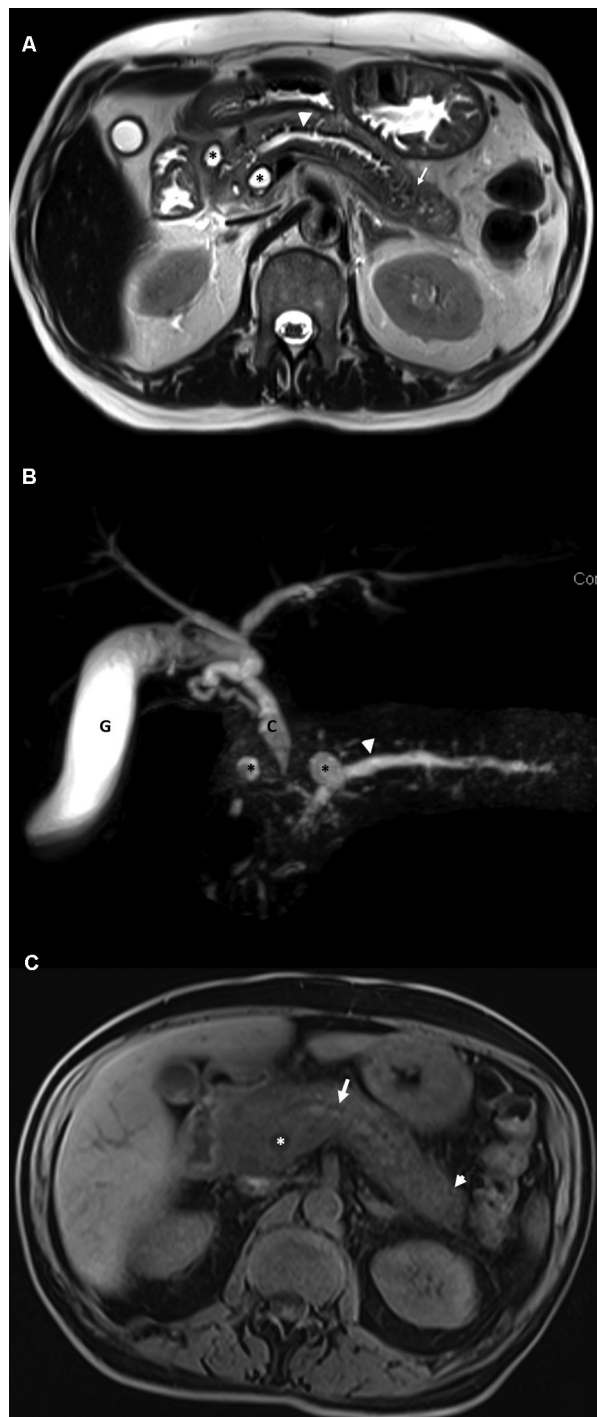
Magnetic resonance imaging (MRI) in 62/M with recurrent acute alcohol pancreatitis showing early chronic changes on MRI. (A) T2 HASTE (half-Fourier acquired single-shot turbo spin echo) in axial plane shows bulky pancreas (white arrow) with a dilated pancreatic duct (white arrowhead) in the body. The black star represents pseudocysts. (B) Three-dimensional (3D) maximum intensity projection (MIP) magnetic resonance cholangiopancreatography (MRCP) shows dilated and tortuous pancreatic duct with few early dilations of side branches (white arrowhead). C is common bile duct (CBD), G is gallbladder. (C) T1-weighted (T1W) fat-suppressed (FS) in axial plane shows the pancreas as low signal intensity (white arrowhead). The white arrow is the pancreatic duct. The white star is a pseudocyst.
